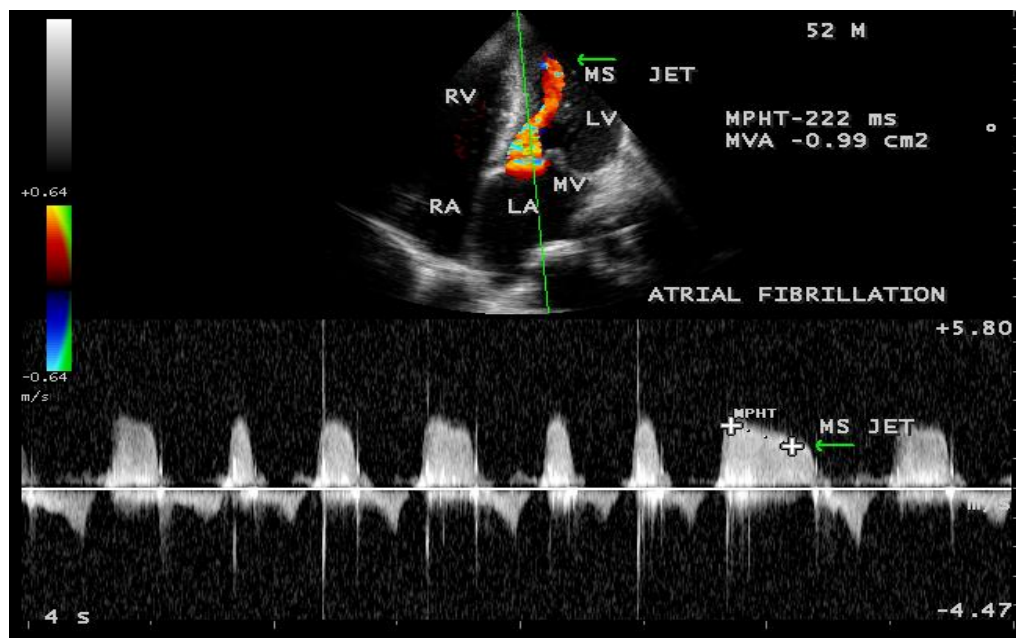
CW (continuous wave) Doppler showing the severe mitral stenosis.
